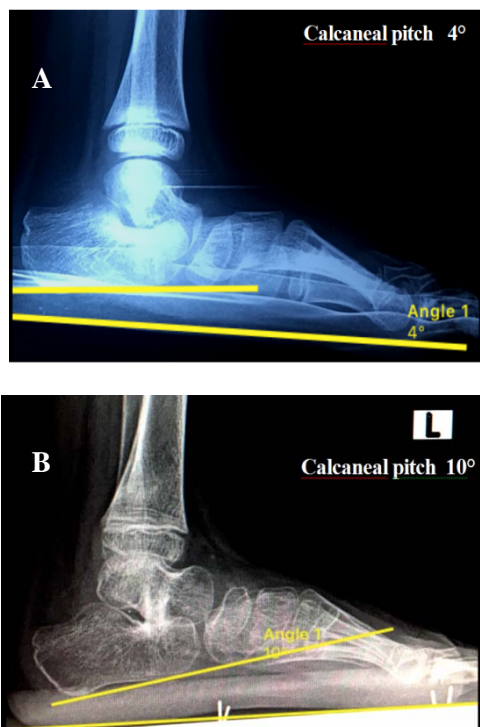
Radiographs showing measurement of preop. (A) and postop. (B) calcaneal pitch angles.
